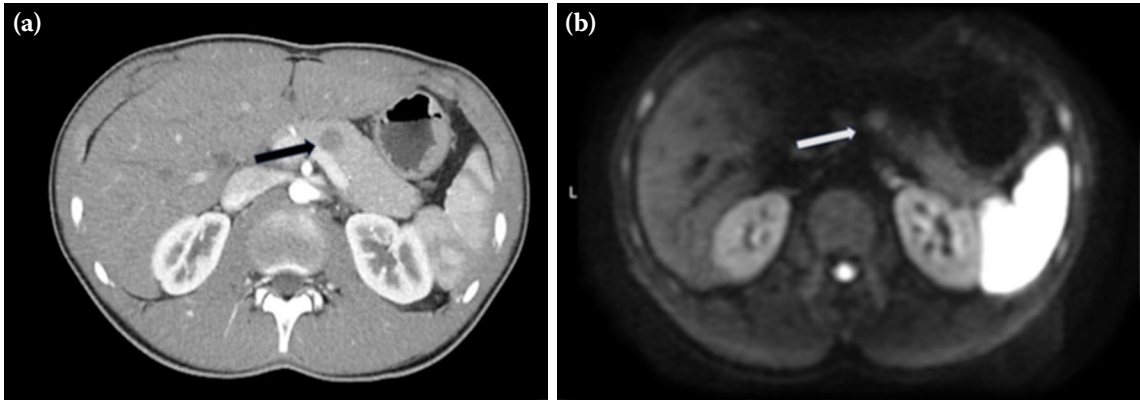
(a) Computed tomography section of the mass (shown with black arrow). (b) Magnetic resonance imaging section of the mass (shown with white arrow).
